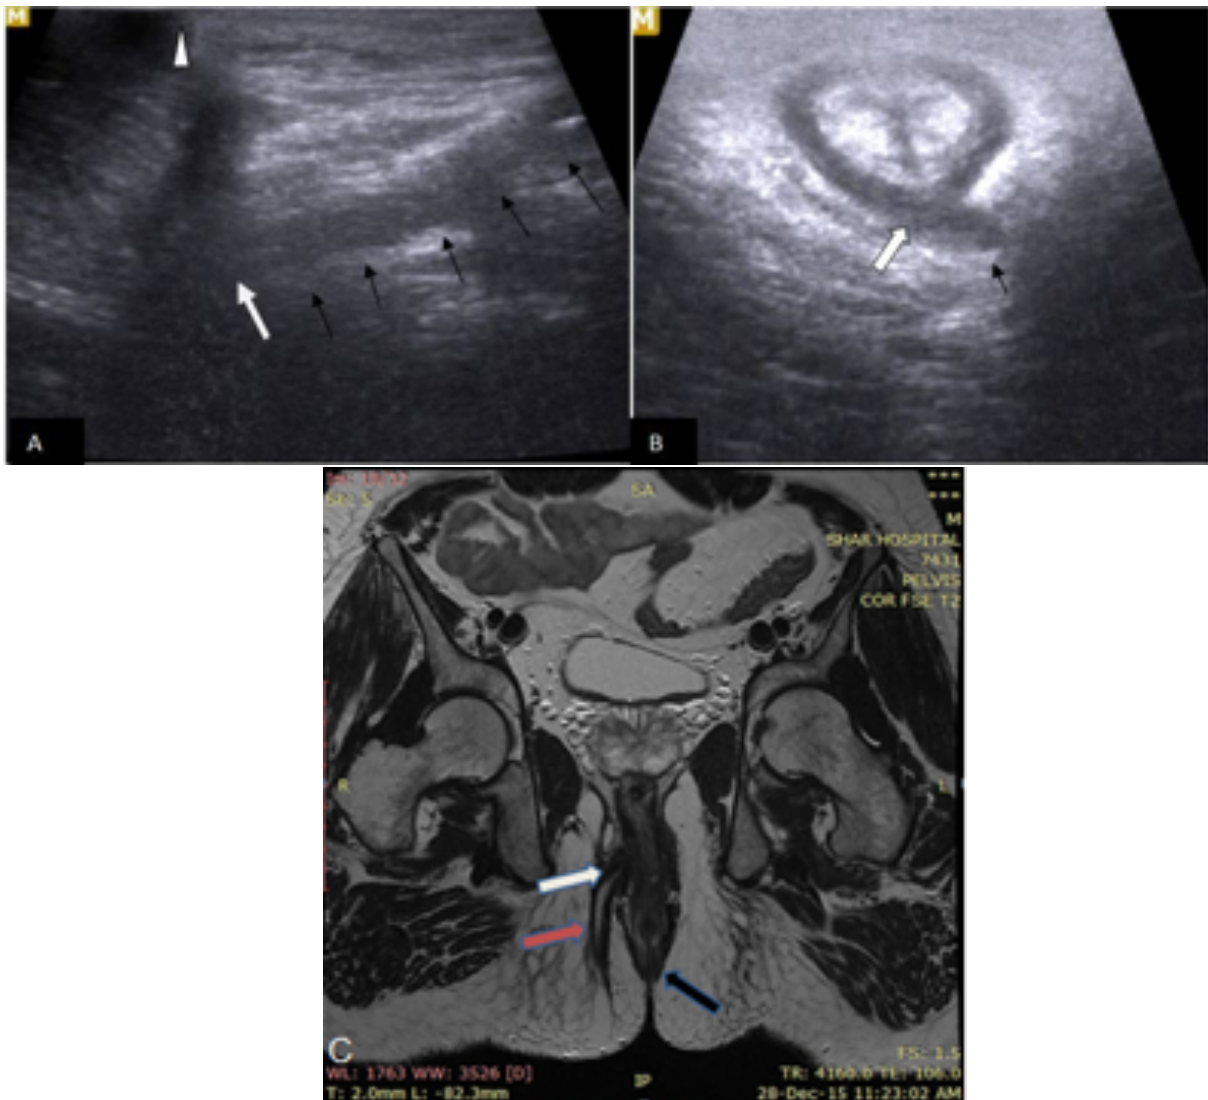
Trans-sphincteric fistula in ano. 1- TPUS longitudinal and axial sections (A and B) along line of the tract (black arrows) which is extended deep through ischo-anal fat and traversing external anal sphincter (white arrow) at a considerable distance from the anal verge (arrow head). 2- Coronal T2WI MRI; showing tract, (pink arrow) and site of traversing anal sphincters and internal opening (white arrow) at the considerable distance from the anal verge.
